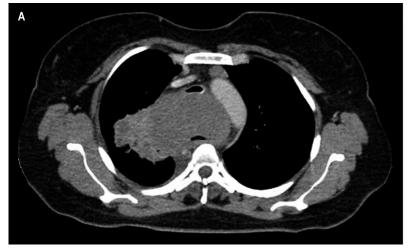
Contrast enhanced chest CT scan. 128 x 66 x 84 mm (L x AP x T) mass located in the middle mediastinum, without significant enhancement after the administration of the contrast medium. The mass is homogeneous, has partially defined lobulated contours, and extends from C7 to T7 with a compressive effect on the adjacent mediastinal structures, especially the trachea, that displaces the tissue in an anterior direction with a decrease in its caliber of approximately 73%; and in the esophagus, where its lumen is partially observed. Prevascular subcentimeter lymph nodes, where the largest one has a short axis of 8 mm; para-aortic lymph nodes with a short axis of 10 mm are also observed. A. Axial view. B. Sagittal reconstruction.
